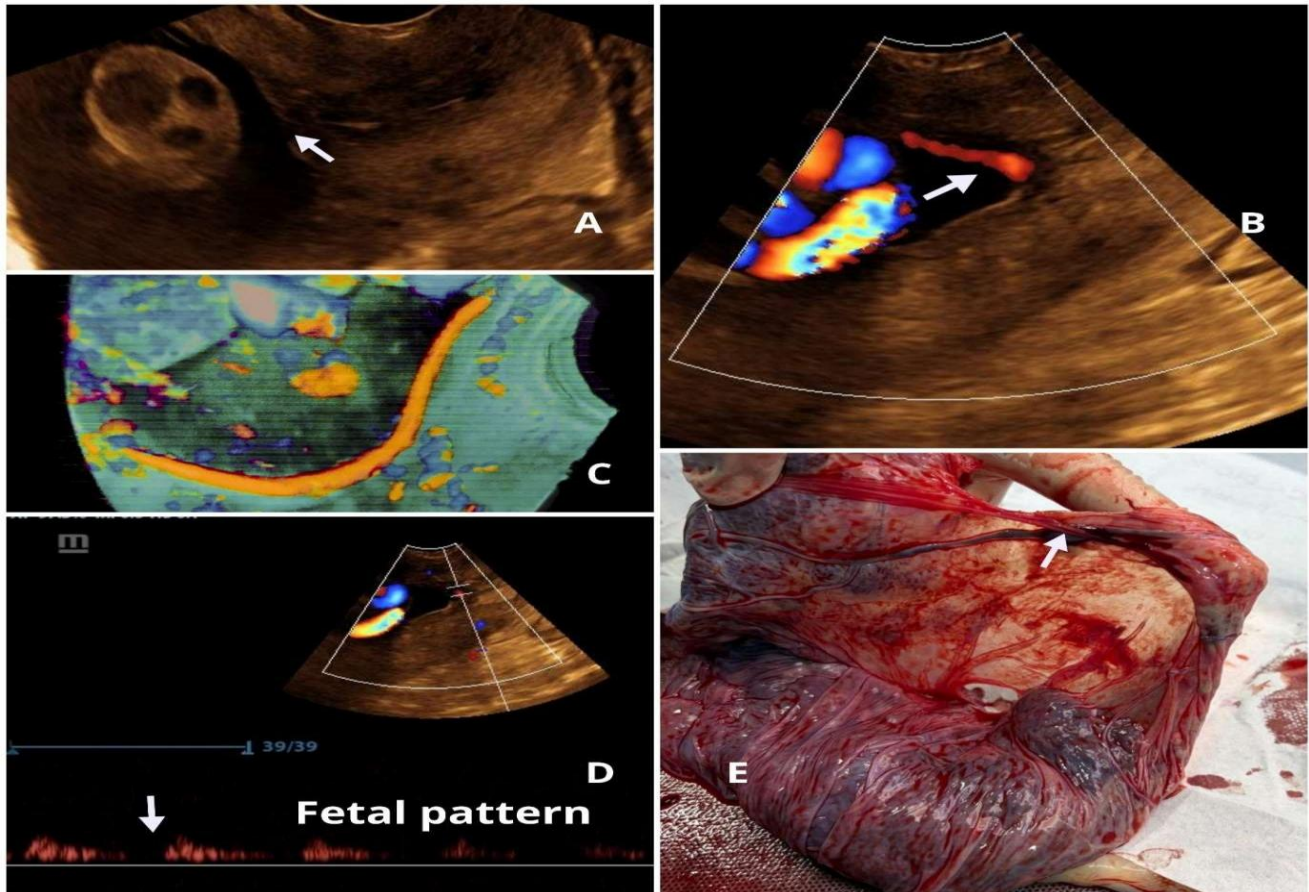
(A-E)-B mode ultrasound showing hypoechoic vessel at internal os. (B)-colour doppler shows arterial flow in the unsupported vessel. (C)-3 D imaging confirmed the presence of unsupported vessel. (D)-Power Doppler showing fetal blood flow pattern in the unprotected blood vessel confirming vasa previa. (E)-Placenta with unsupported fetal vessel running within the membrane from one edge of the placenta to the other.
